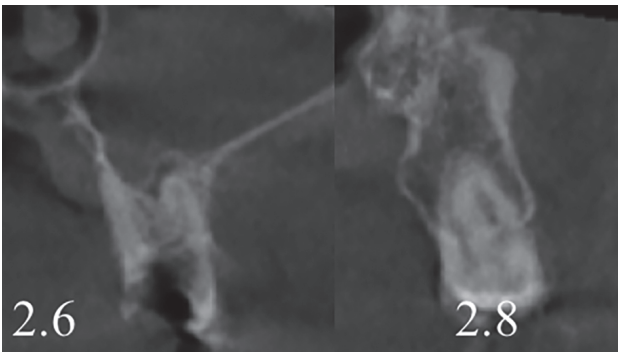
Cone beam scan, where the apical radiolucent image associated with the root remains of 2.6 and the conical root of 2.8 are seen.
